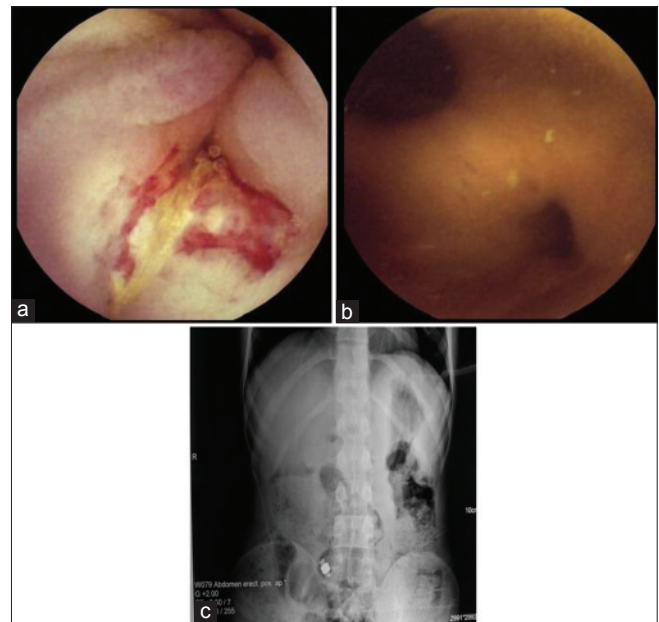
A 20-year-old male with abdominal pain, recurrent malena. Capsule endoscopy reveals: (a) ulcer in ileum (b) two diverticulae in ileum. (c) Abdominal X-ray showing capsule retention in ileum
